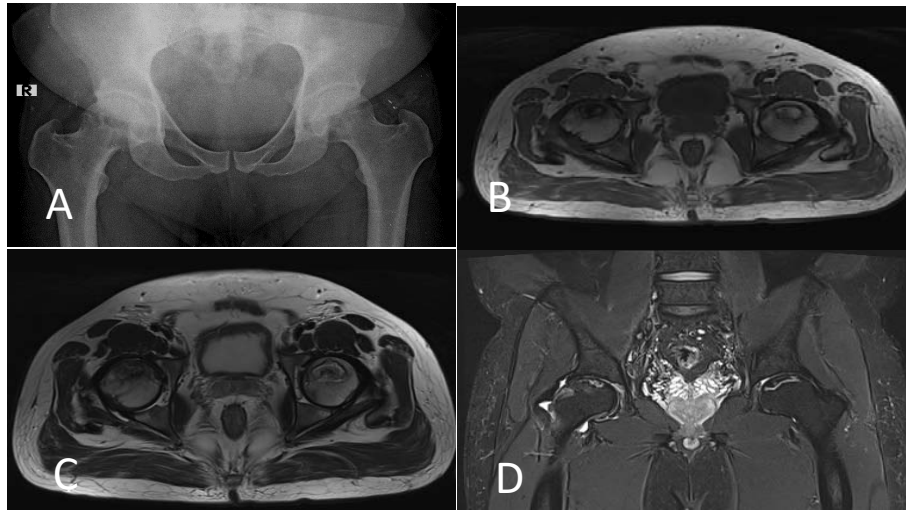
AP radiograph pelvis(A) showing mild sclerosis of bilateral femoral heads with normal contour. MRI T1,T2 axial (B,C) and STIR coronal images(D) showing Geographical areas of altered signal intensity areas which are heterogeneously hyperintense on T1,T2 with surrounding hypointense rim with central suppression and peripheral hyperintense rim on STIR in both femoral heads. F/S/O bilateral grade II AVN.
